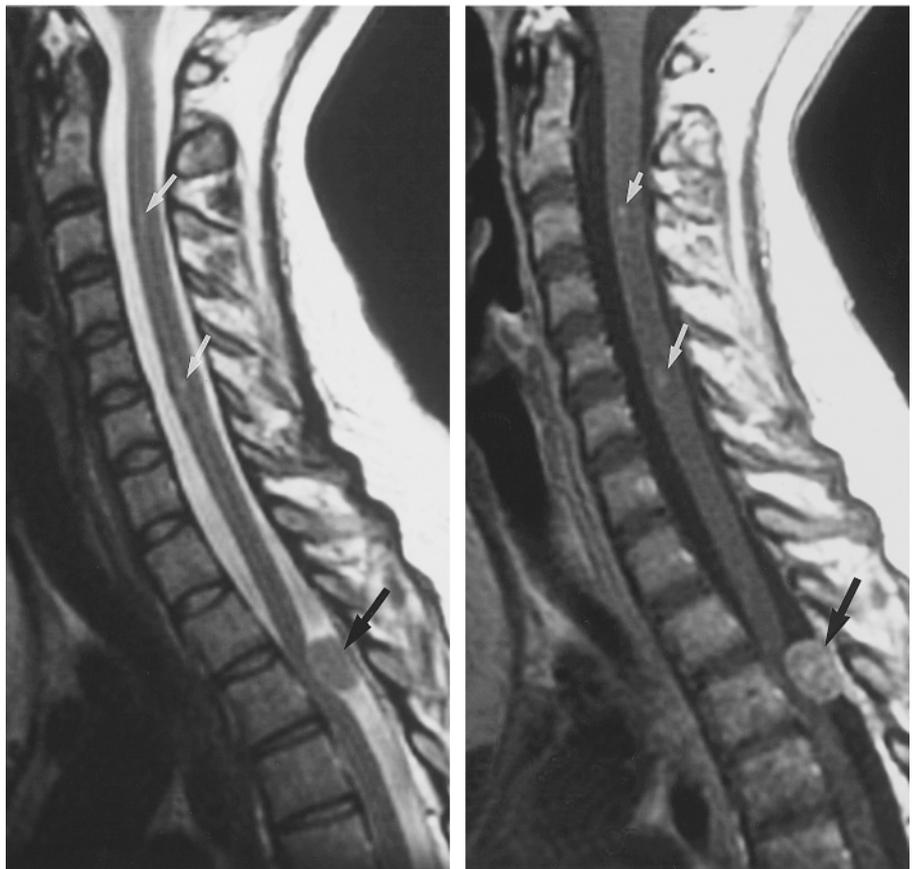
(a) Sagittal T2-weighted MR image (3,500/100) of the cervical and upper thoracic spine. A rounded extraaxial mass is depicted in the spinal canal at the level of T3 and compresses the cord (black arrow). Two small focal hyperintense areas (white arrows) are also identified in the cord near the central canal at the C3 and C5-C6 levels. (b) Sagittal contrast-enhanced T1-weighted image (500/8). Mass lesion (black arrow) at T3 demonstrates homogeneous enhancement and represents an NST. Two additional lesions (white arrows) identified within the cord are also enhanced; they represent intramedullary tumors.
